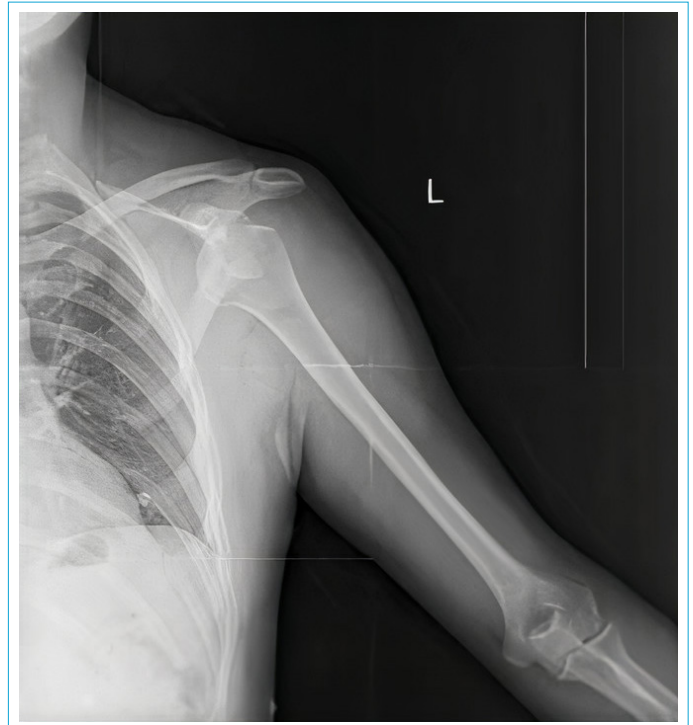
Male patient, 39 years old; AP X-rays of the left shoulder show bilateral anterior shoulder dislocation.
